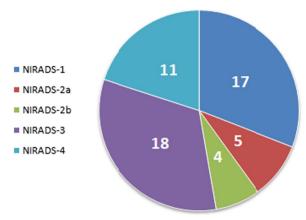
Classification of cases according to their score of NI-RADS in PET/CT report
